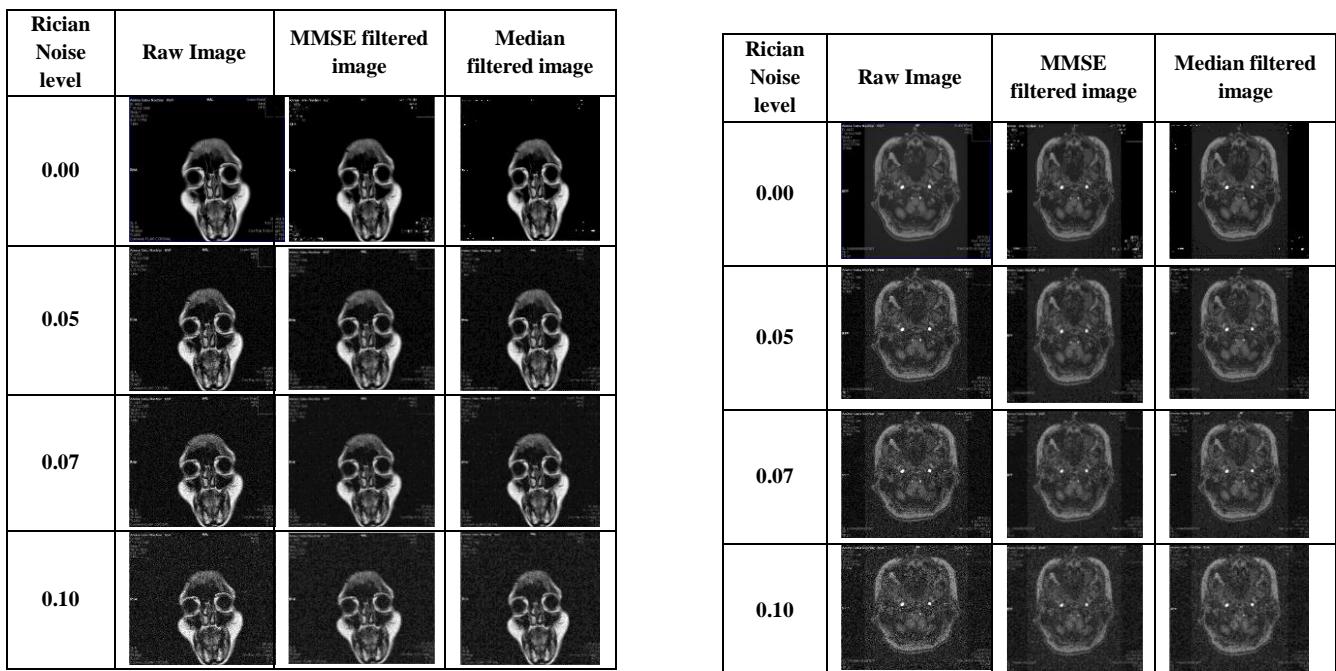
Rician noise corrupted, MMSE and Median filtered MR images SP A5.4
